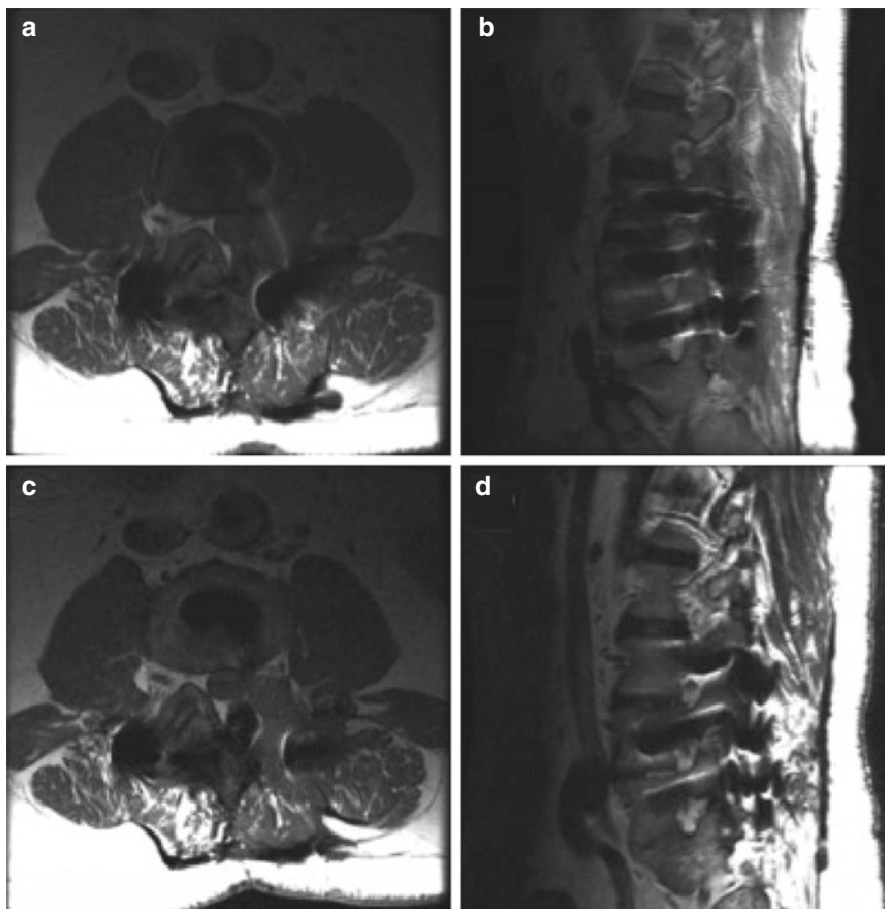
Images showing the results of a minimally invasive approach with an expandable tubular retractor to resect a left L3–L4 schwannoma found 2 years after a spinal fusion. By using a tubular retractor placed via a Wiltse approach, we did not have to remove any of the hardware. Preoperative axial (a) and sagittal (b) MRI imaging. Postoperative axial (c) and sagittal (d) images following gross total resection of tumor. (Originally published in Lu et al. *J Neurosurg Spine* 2009 [50]; reprinted with permission)
